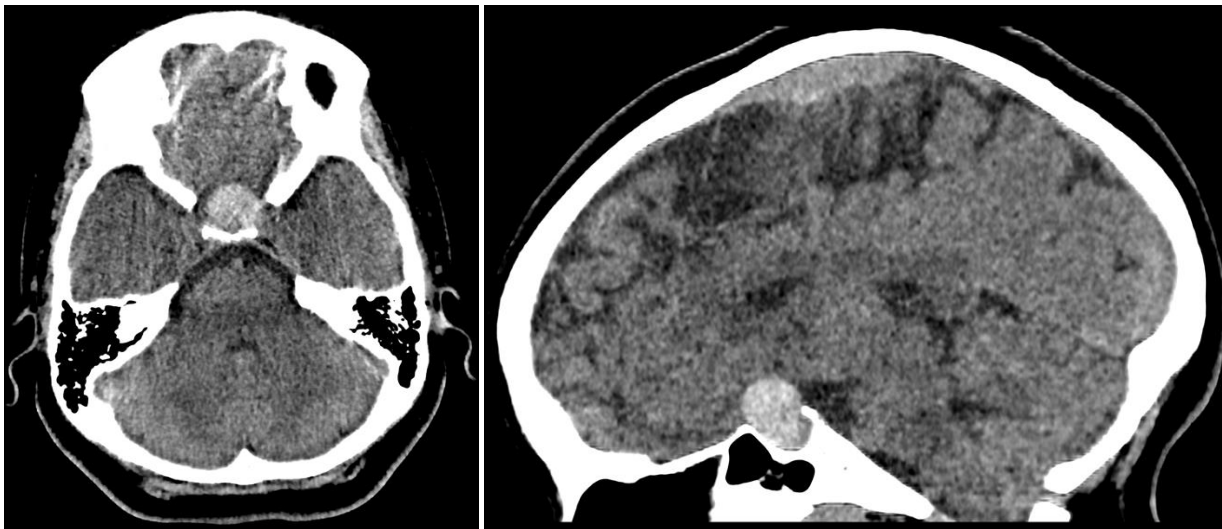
Axial and sagittal plain CT Brain images showing a well-defined intrasellar hyperdense lesion with suprasellar extension.
